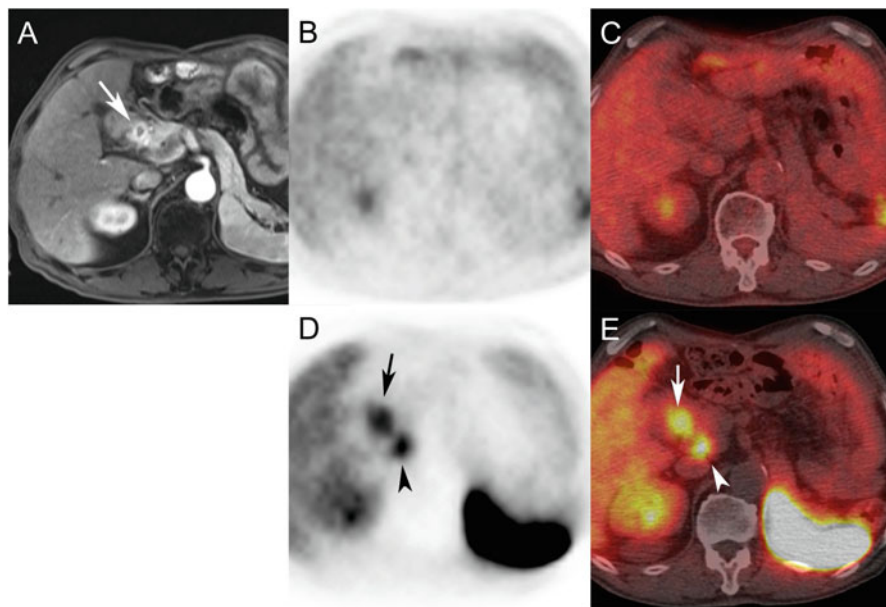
A 76-year-old man with a hypervascular pancreatic tumor. Contrast-enhanced MR (a), FDG PET (b), FDG PET/CT (c), DOTATOC PET (d), and DOTATOC PET/CT (e) images are shown. The contrast-enhanced MR image (a) shows a well-enhanced mass in the pancreatic head (arrow). The FDG PET image (b) shows no abnormal uptake corresponding to this lesion, but the DOTATOC PET (d) and the DOTATOC PET/CT (e) images show DOTATOC accumulation in this tumor (arrows). A pancreatic neuroendocrine tumor and pancreatic metastasis from renal cell carcinoma was suspected. The final diagnosis was metastatic pancreatic tumor from renal cell carcinoma. Physiological uptake in a part of pancreas is also seen on the DOTATOC PET images (arrowheads)
